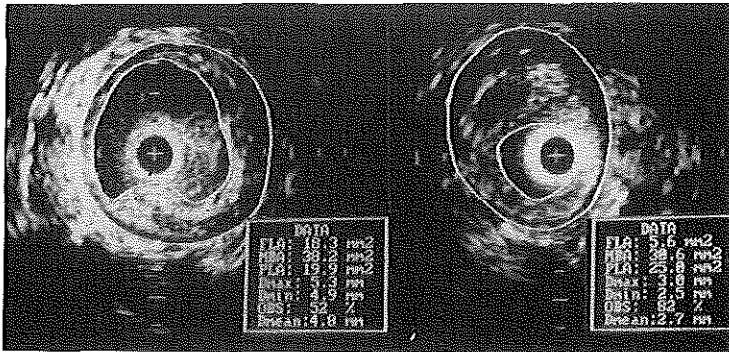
Intravascular ultrasound (IVUS) cross-sections of the femoropopliteal artery in a patient after PTA (left panel) and at 6-months follow-up (right panel). The cross-sections are contour traced off-line facilitating recognition and measurement of lumen area (FLA, inner contour) and media-bounded area (MBA, outer contour). The lumen area (FLA) decreased from 18.3 mm² to 5.6 mm². The media-bounded area (MBA) decreased from 38.2 mm² to 30.6 mm². The plaque area increased from 19.9 mm² to 25.0 mm². + = catheter; calibration = 1 mm.
